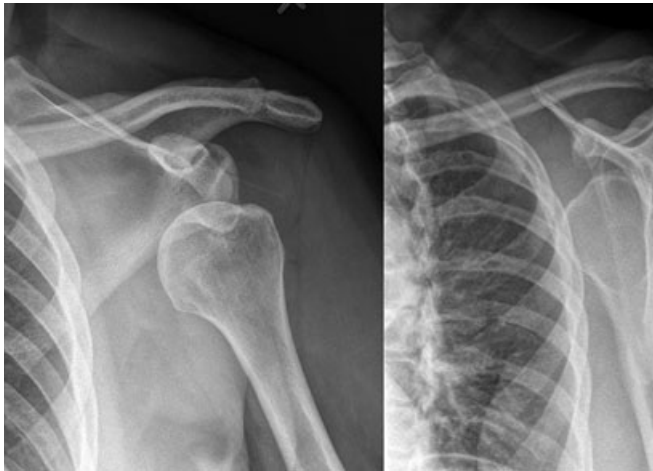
Anteroposterior and scapular Y radiographs demonstrate subcoracoid glenohumeral dislocation.
